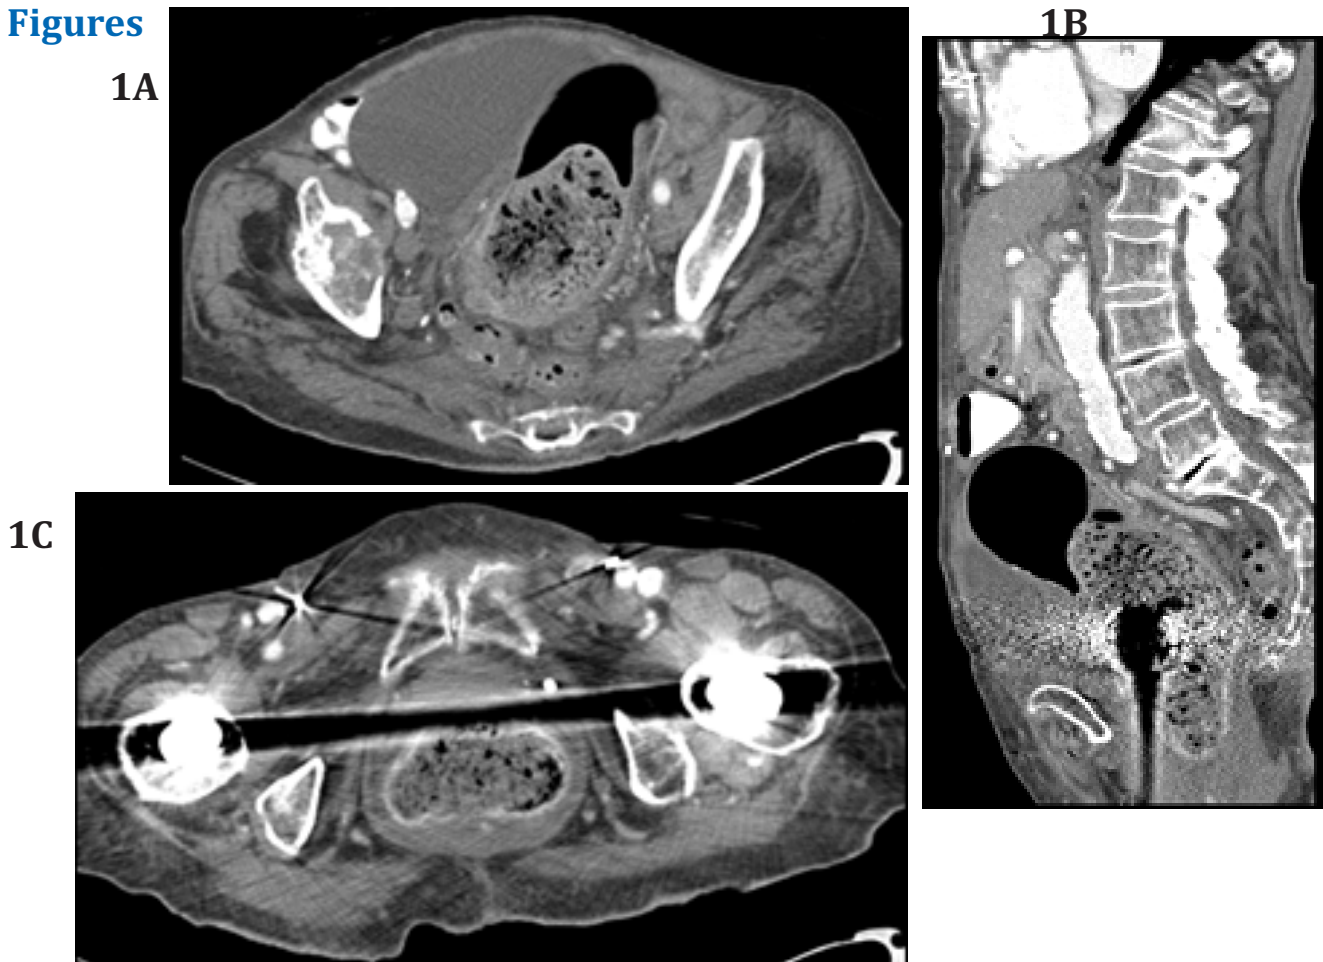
CT scan of the abdomen with contrast. (Fig 1A): Transverse section showing fecaloma causing dilation of the proximal sigmoid colon to 7.7 cm in diameter. (Fig 1B): Sagittal section showing dilation extending from the proximal sigmoid colon to the rectum with evidence of impaction, stranding of mesenteric fat, focal asymmetric colonic wall thickening. (Fig 1C): Transverse section showing marked thickening of the rectal wall, with mural contrast enhancement.
